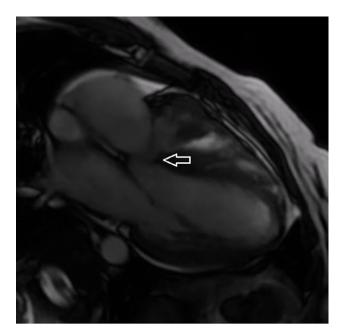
Cardiac MRI. White arrow: subaortic ventricular septal defect. Note the overriding aorta.
